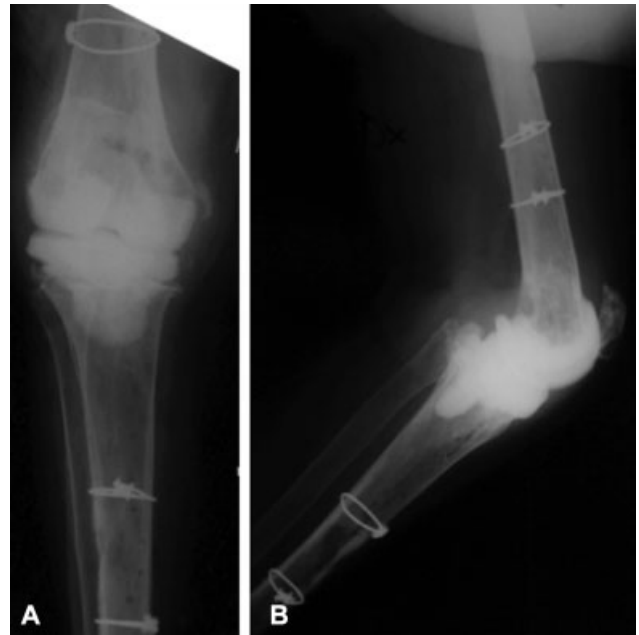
Anteroposterior (A) and lateral (B) X-rays show a handmade cement spacer.
